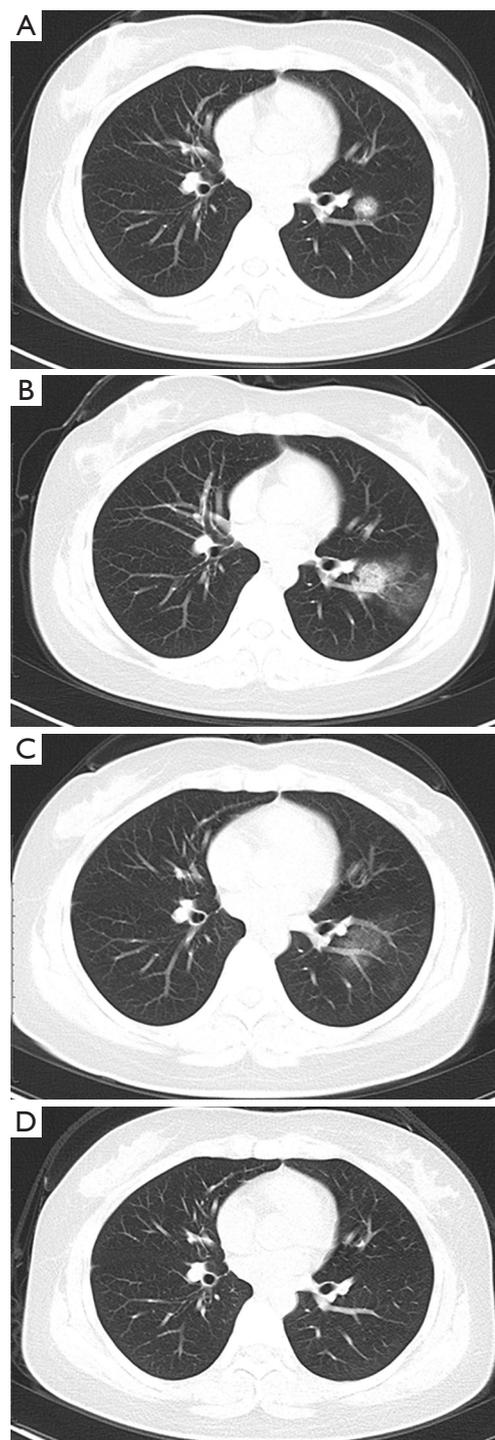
Pulmonary nodule in a 23-year-old female with confirmed COVID-19. (A) Initial CT image on January 26, 2020 shows a nodule in the left lower lung. (B,C) The lesion progressed with a patchy shadow on CT images taken on January 30 and February 5, 2020. (D) CT scan on March 2, 2020 shows resolution of the nodule.
